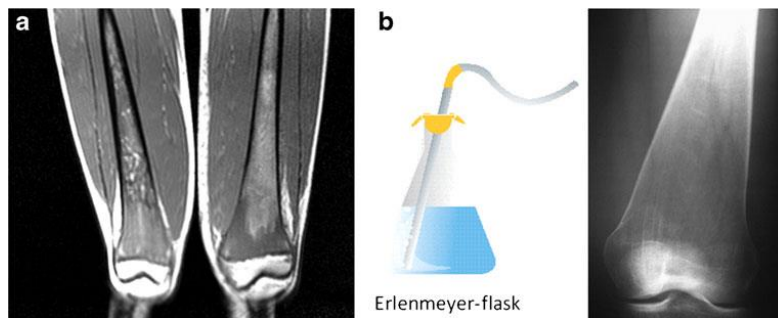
a. MRI showing marrow infiltration. b. X-ray showing Erlenmeyer flask deformity. Modified from Orvisky et al. [10].
